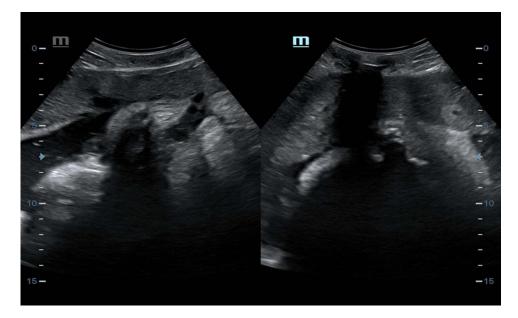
Figure I Obstetric ultrasound image at a gestational age of 25w +5d, showing a placental bed closely opposed to the anterior abdominal wall and an ill-defined amniotic cavity with no uterine wall around the fetus, placenta and amniotic membrane.
